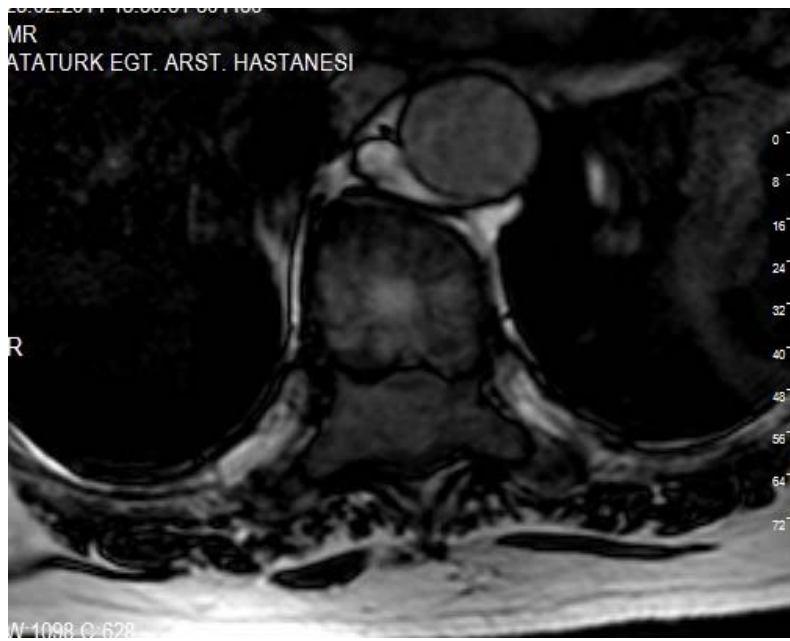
Axial MRI section showing epidural mass with cord compression at T7-T8 level.
